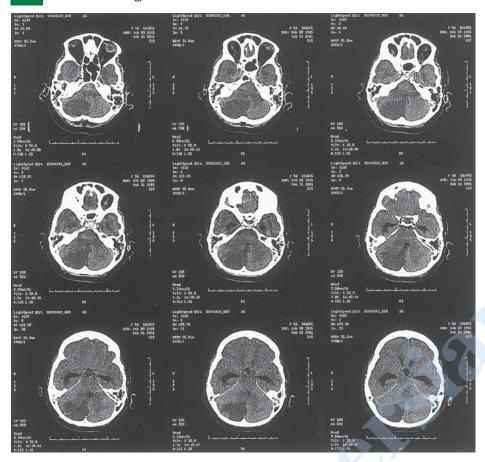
Axial unenhanced CT demonstrates a large area of low attenuation involving the inferior and posterior aspects of the right cerebellar hemisphere (territory of the posterior—inferior cerebellar artery) causing effacement of the brainstem cisterns and compression of the fourth ventricle, causing acute obstructive hydrocephalus. The patient required a right occipital craniectomy secondary to her large edematous cerebellar infarction.
